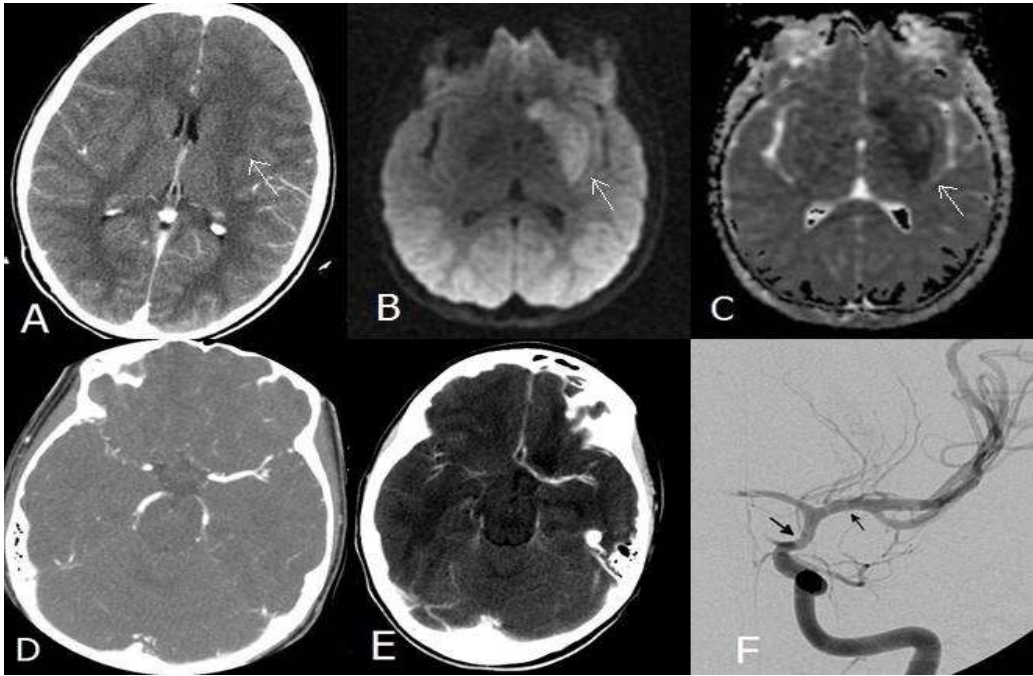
An 11-year-old, previously healthy, right-handed girl with acute left basal ganglia ischemic stroke presented with slurred speech, decreased level of consciousness and right hemiparesis. A) Head computed tomography (CT) 8 hours after initial onset of symptoms revealed hypodensity in the region of the left lentiform nucleus consistent with an acute infarct. B and C) Magnetic resonance imaging (MRI) at 21 hours post-stroke demonstrated diffusion restriction in the left lentiform nucleus with a corresponding apparent diffusion coefficient map (B) in that region. D and E) Her contrast enhanced CT angiogram and MR angiogram were normal. F) A subsequent cerebral catheter angiogram demonstrated narrowing and irregularity in the distal segment of the left internal cerebral artery, proximal M1 segment of left middle cerebral artery and the A1 segment of the left anterior cerebral artery (arrows).
